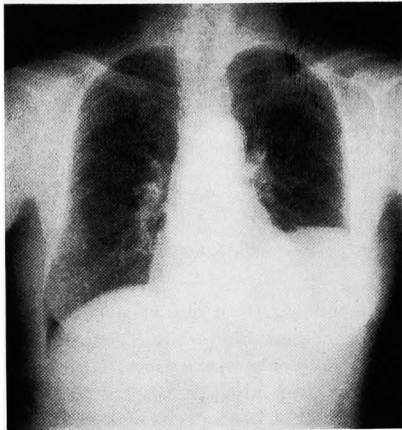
Chest X-ray revealed the left portion of the diaphragm being pushed up by the spheroid tumor mass.
